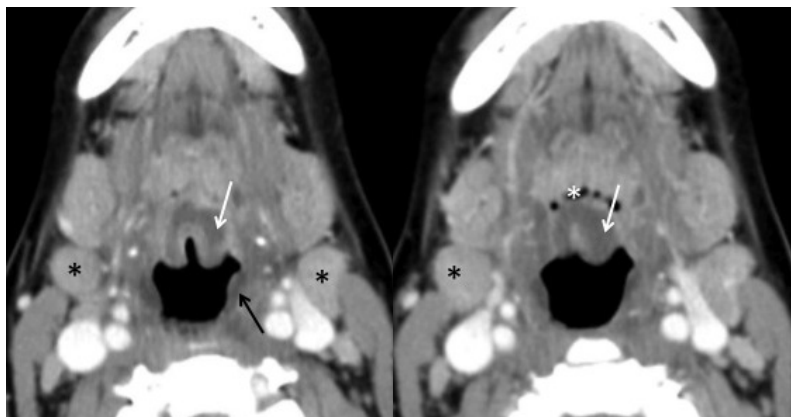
Epiglottitis. Axial contrast enhanced CT above the hyoid bone level, shows an enlarged and edematous epiglottitis (white arrow), with mild thickening of the pharyngeal mucosa (black arrow) without extension to vallecula (*). Mild reactive bilateral upper internal jugular chain lymphadenopathies (level II) were also found (black *).
